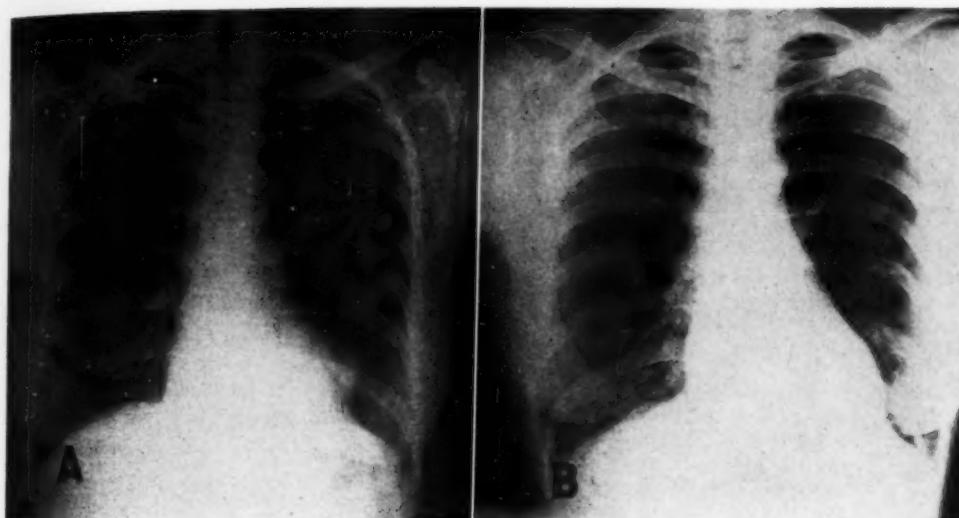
A. Gumma of left ventricle, indistinguishable from tumor on x-ray films. Fluoroscopy revealed a striking paradoxical pulsation (expansion) of the protruding area with each ventricular systole.
